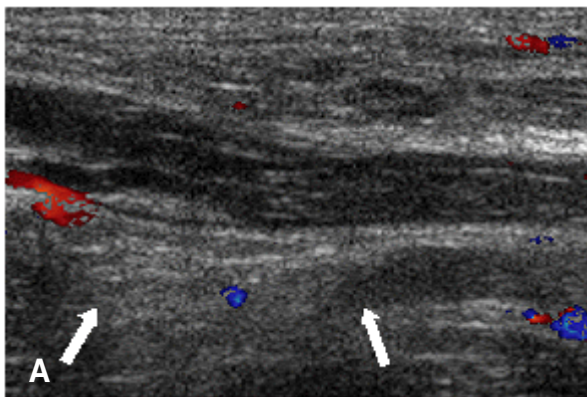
Initial color Doppler ultrasonogram (A) shows obstruction of the right axillary vein (white arrow). Two months later color Doppler ultrasonogram (B) demonstrates a completely resolved thrombosis within the right axillary vein (black arrow).
